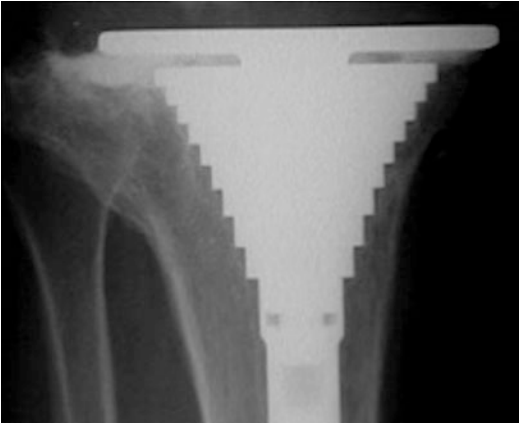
Radiograph demonstrates how tibial stem drove the tibial tray medial due to a lack of offset options with this sleeve/tray construct
